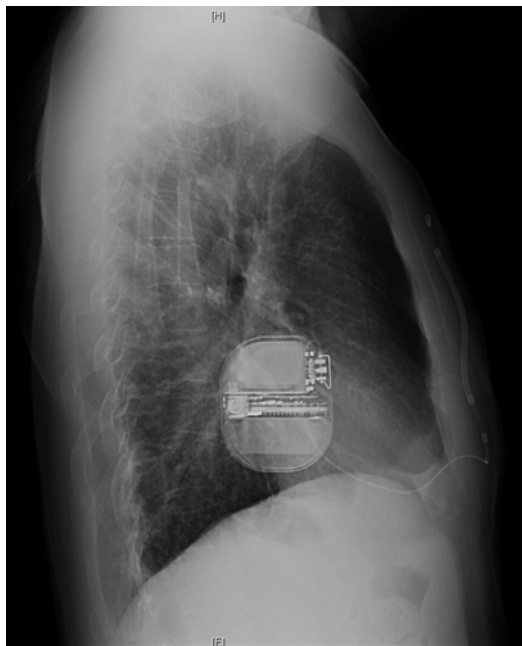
Chest X-ray lateral view
